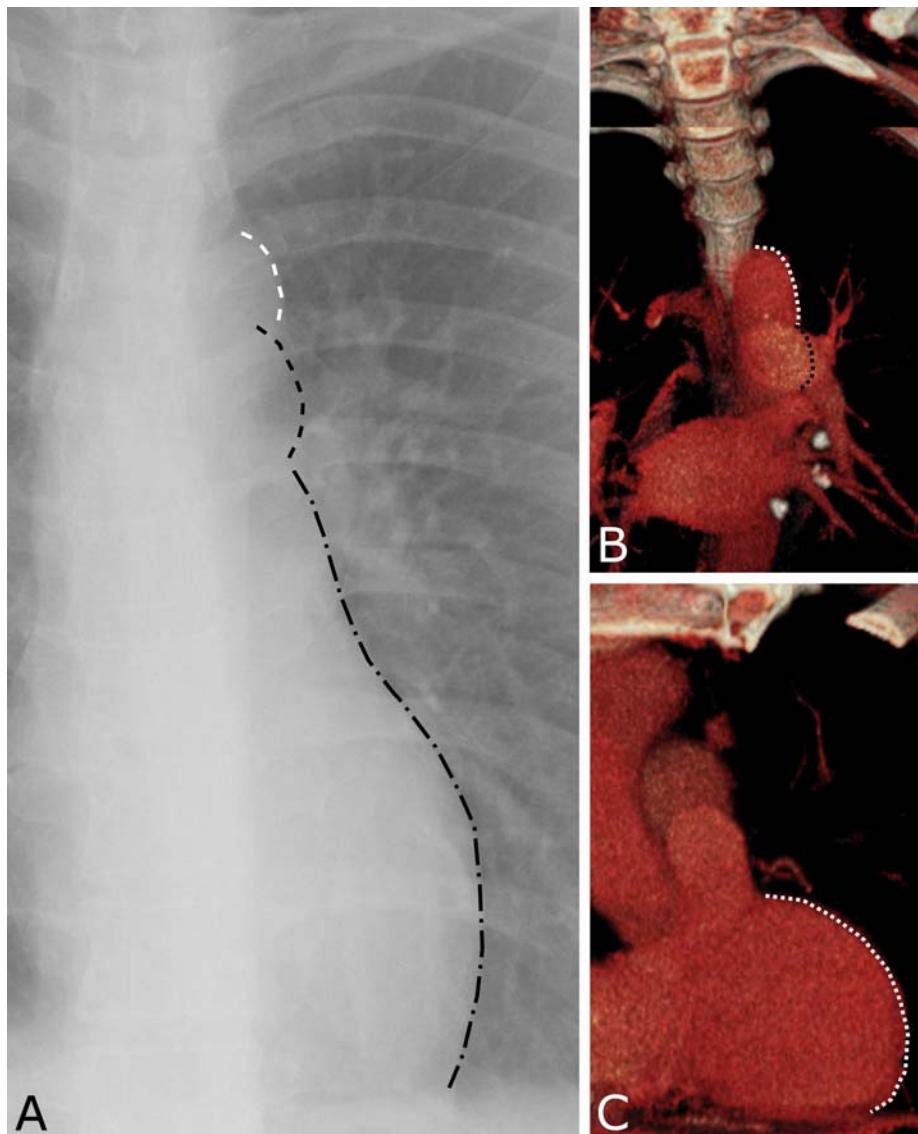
Left mediastinal border. A. Frontal radiograph shows aortic knob (white dashes), main pulmonary artery (black dashes) and left ventricle (black dot-dash). B and C. Volume rendered CT images to show the same structures. B. Aortic knob (white dots) and main pulmonary artery (black dots). C. Left ventricle (white dots).
